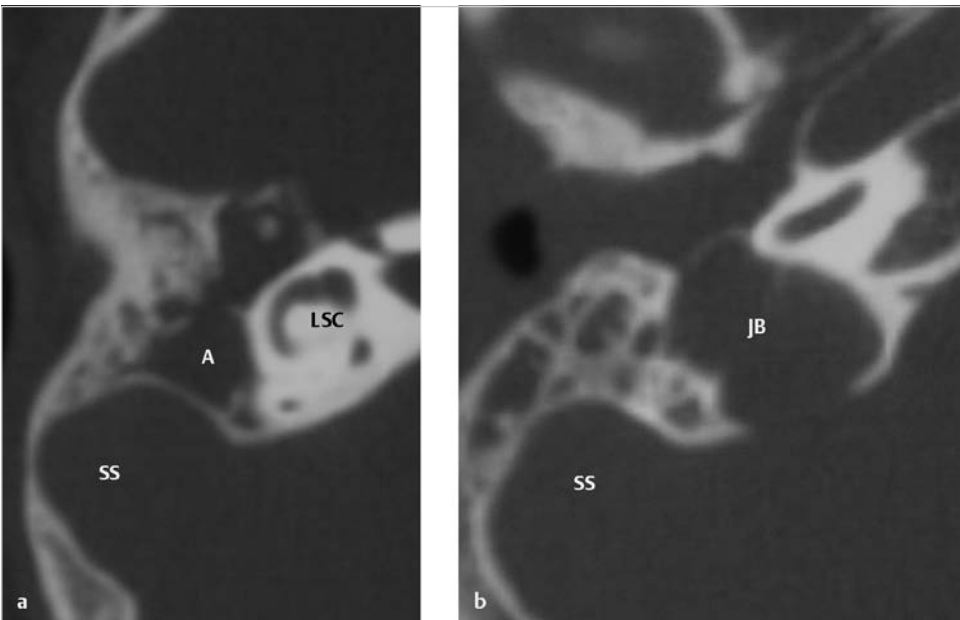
A case of cholesteatoma with prominent sigmoid sinus is shown. (a) The axial CT demonstrated that the protruded sigmoid sinus narrow access to the antrum. (b) The more caudal slice demonstrates a large jugular bulb in the tympanic cavity. A, antrum; JB, jugular bulb; LSC, lateral semicircular canal; SS, sigmoid sinus.
